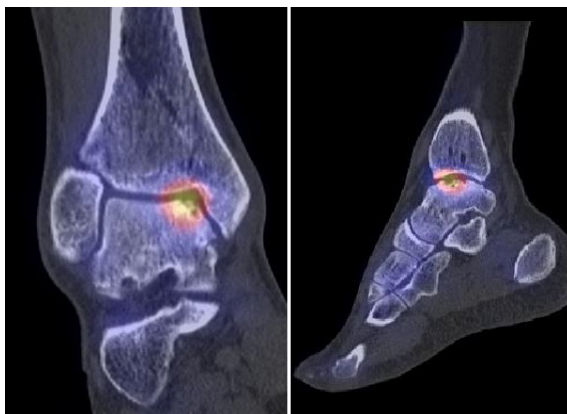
SPECT/CT with osteochondral lesion at the talus
